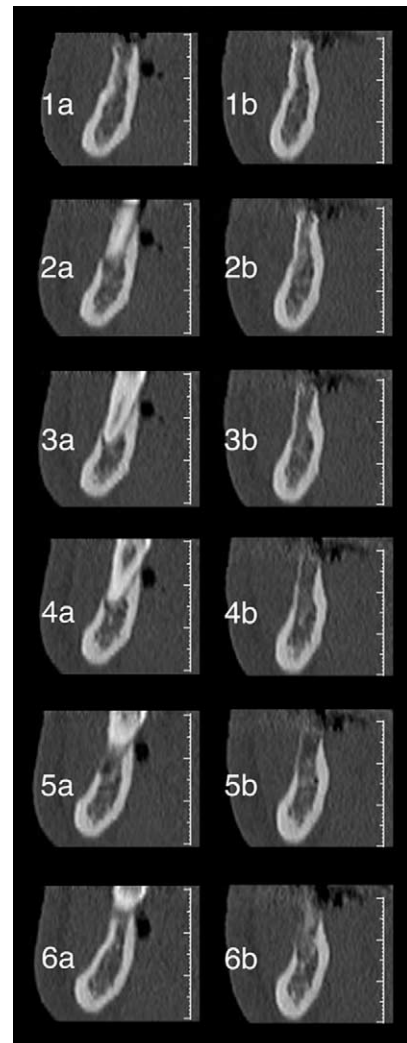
Orthoradial CT reconstructions of 6 measured points. 1a-6a, Pretreatment stage; 1b-6b, posttreatment stage.
